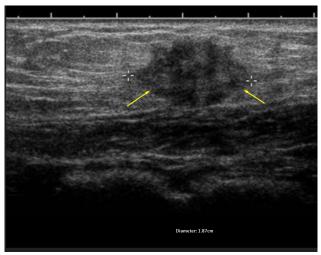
Superficial ultrasonography of abdominal wall endometrioma.
